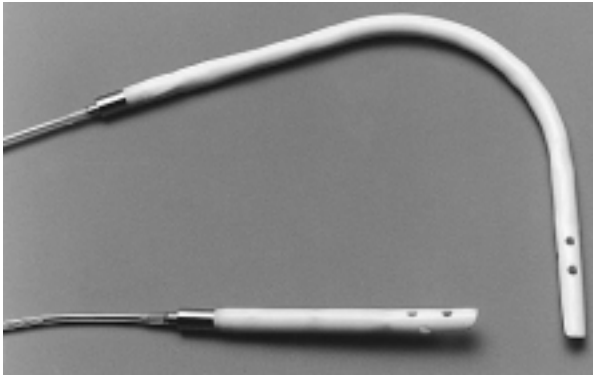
The Hemopump cardiac assist system is a miniaturized axial rotary blood pump. There were two cannulas in clinical use: the long femoral type and the short transthoracic type. Both are 8.1 mm wide.
